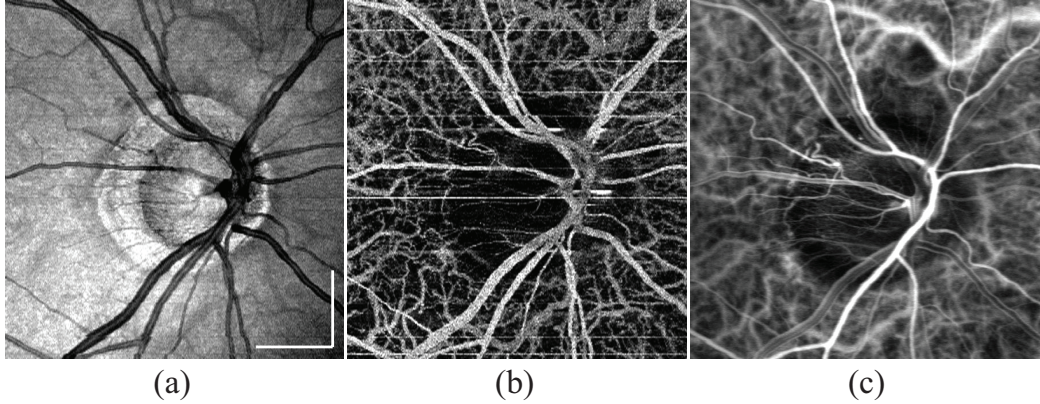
En face* projection images of an ONH. (a) global-phase-corrected sensitivity-enhanced scattering OCT, (b) power of Doppler shift and (c) ICGA. The scale bar represents  $1 \text{ mm} \times 1 \text{ mm}$ . (Source: Ju et al. *Advanced multi-contrast Jones matrix optical coherence tomography for Doppler and polarization sensitive imaging* [90])
